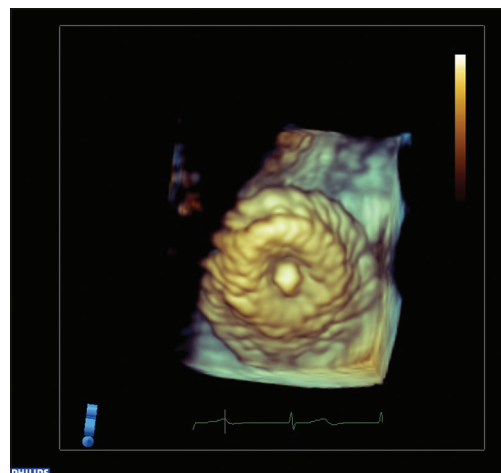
A perioperative three-dimensional transesophageal echocardiography image from a patient who underwent secundum atrial septal defect closure using an atrial septal occluder
